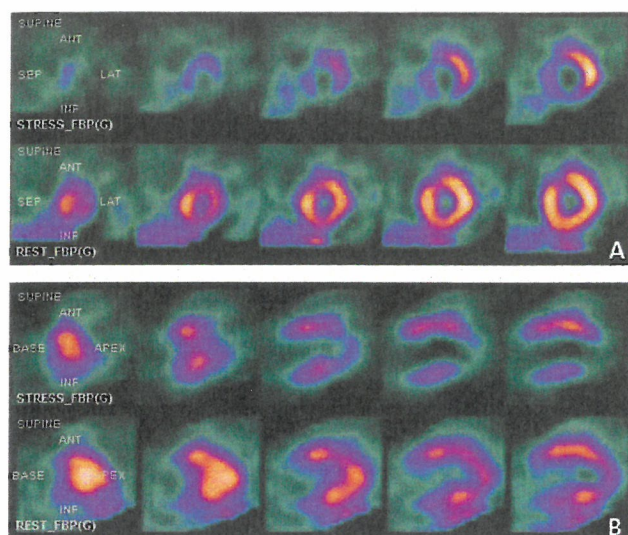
Selected images from a nuclear perfusion single-photon emission CT (SPECT) stress study. Short-axis views (*panel A*) of the heart with stress (*top row*) and at rest (*bottom row*) show a radiotracer defect in the septum and inferior wall that is filled on the rest images. Long-axis views (*panel B*) demonstrate an apical filling defect with stress (*top row*) that is perfused on rest images (*bottom row*).
